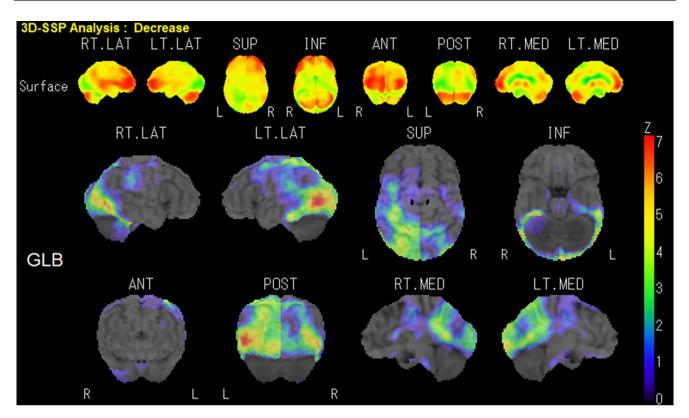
Single-photon emission computed tomography images using 3-D stereotactic surface projection revealed hypoperfusion in the occipital lobe and posterior cingulate gyrus.
